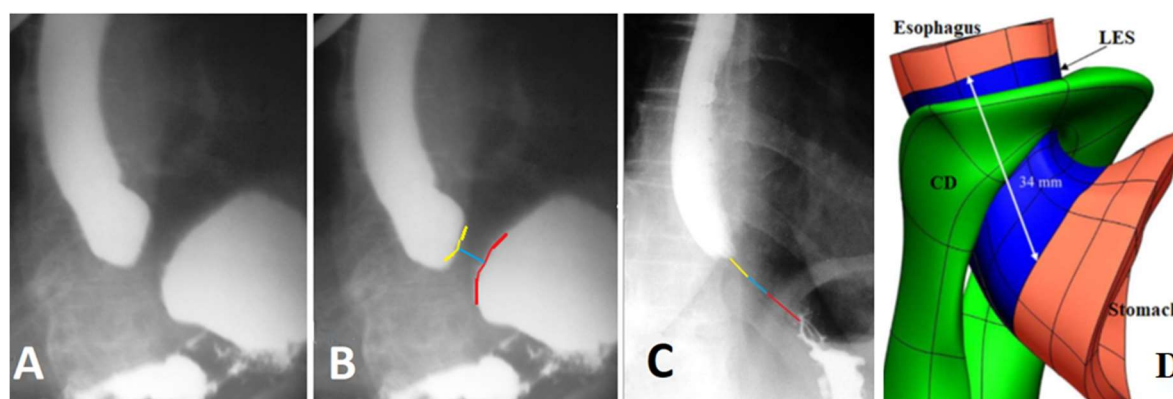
Radiograph (A) and scheme to it (B) of patient with GERD was done in a horizontal position with the abdominal compression. The sharp shortening of the LES because of the opening of the supra-diaphragmatic part of the LES (yellow) and inside the abdominal part of the LES (red) is determined. Only the diaphragm part (blue) of the sphincter is closed. (C) Radiograph of this patient in an upright position taken during abdominal compression. The LES contracted in response to the increased pressure in the stomach. It is visible as two longitudinal folds between the esophagus and stomach. Since the actual height of D-10 is ≈ 2
